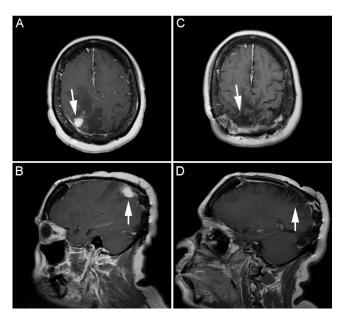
T1-weighted magnetic resonance images (MRIs) of the intracranial lesion showing enhancement (arrow) in axial (A) and sagittal (B) views. Axial (C) and sagittal (D) T1weighted MRIs of the intracranial lesion after tumor resection demonstrate no enhancement (arrow).
